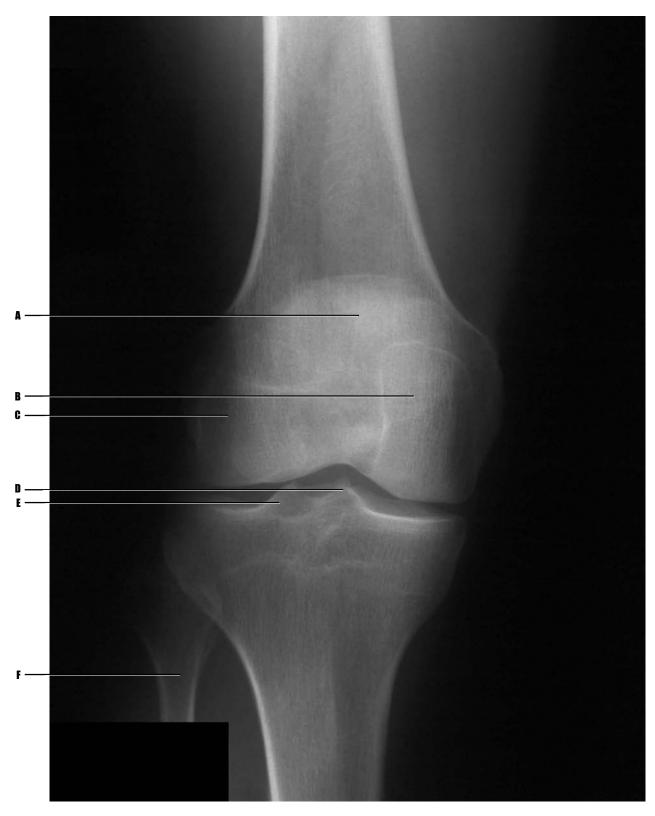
(above) Adult patient, plain film radiograph, posteroanterior view of left knee.
